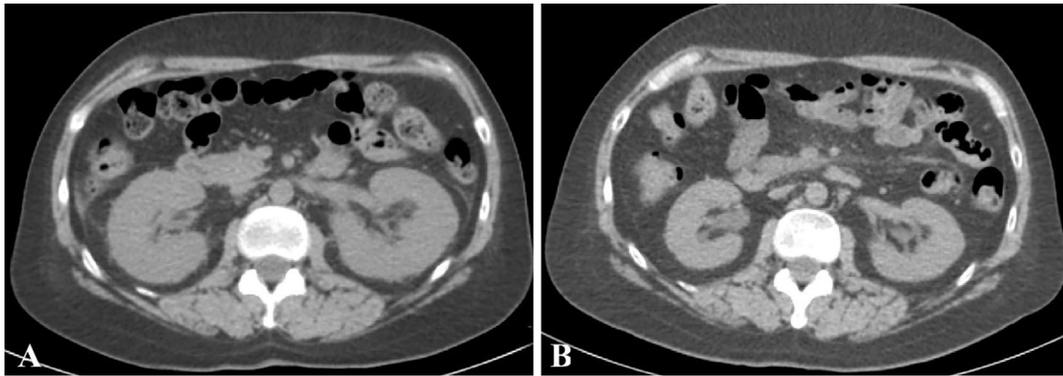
Kidney CT before (A) and after (B) 8 cycles of chemotherapy. CT at diagnosis showed marked bilateral kidney hypertrophy (A) which subsided after 8 cycles of anthracycline-containing chemotherapy associated with rituximab (B).
